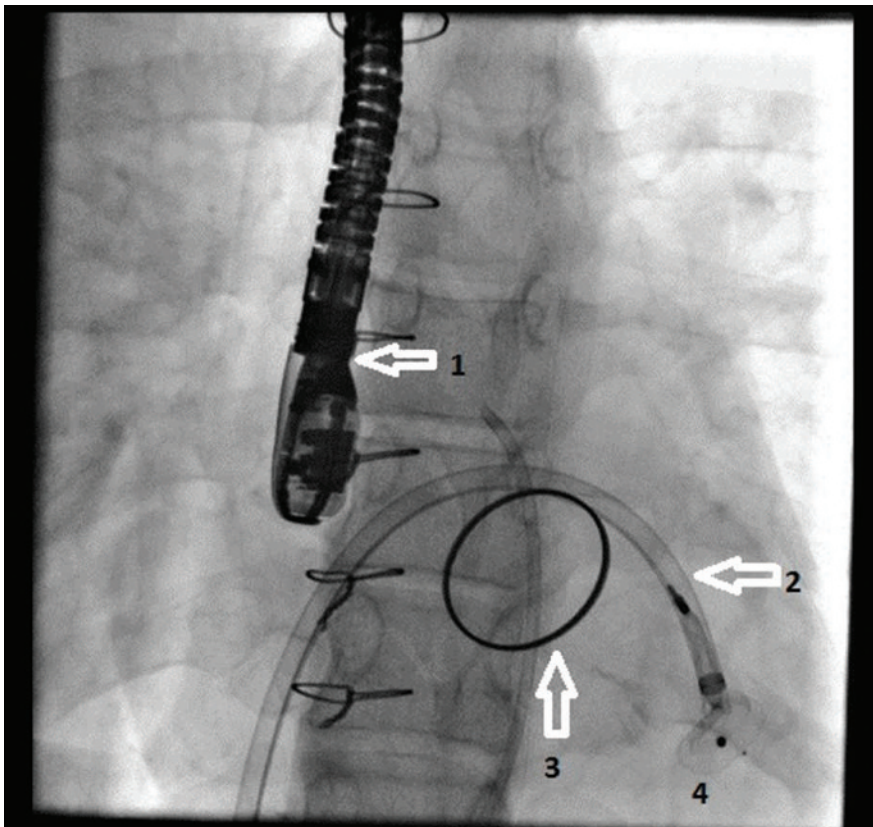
Fluoroscopy shows the femoro-femoral loop. The trans-septal sheath crossing through the paravalvular leak from the left atrium into the left ventricle. The steerable electrode in trans-septal sheath and Amplatzer™ (St. Jude Medical, St. Paul, MN) left catheter with a wire create the loop. Arrows show transesophageal echocardiography transducer (1), arterial catheter (2), trans-septal sheath (3), and ring of implanted mitral valve (4).
